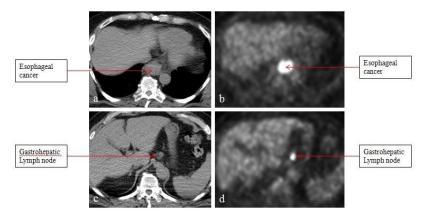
PET/CT scan demonstrates a distal esophageal 18-FDG avid thickening that corresponds to the patients esophageal cancer (a,b). An 18-FDG avid metastatic gastrohepatic lymph node was also noted (c,d). CT scan (a,c); PET scan (b,d). Image courtesy of the UMass Memorial Hospital, Department of Diagnostic Radiology.
